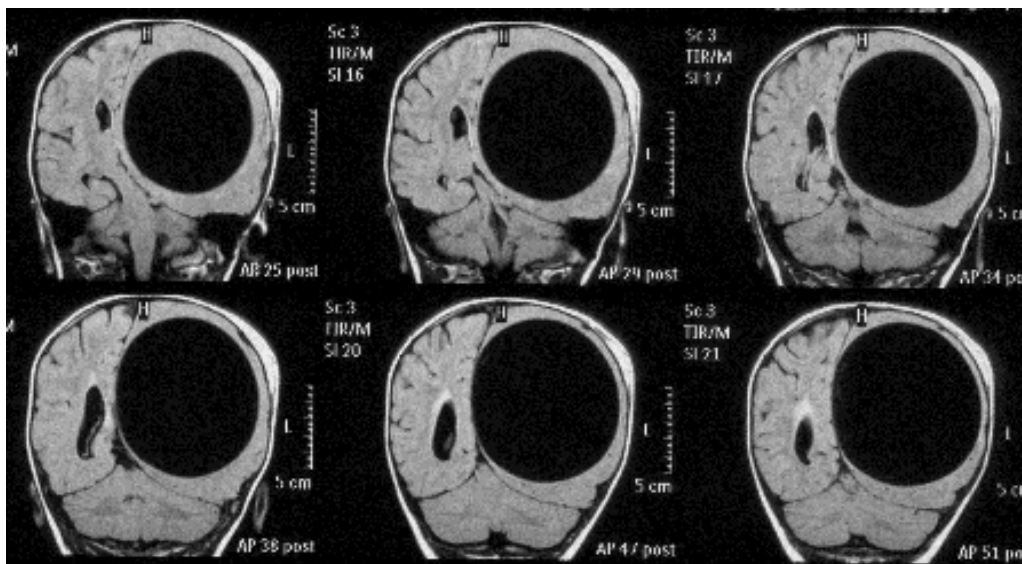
Preoperative MRI: T1 weighted images shows a cystic lesion. Midline shift is 1,5 cm. Also can be seen the epicranial haematoma
